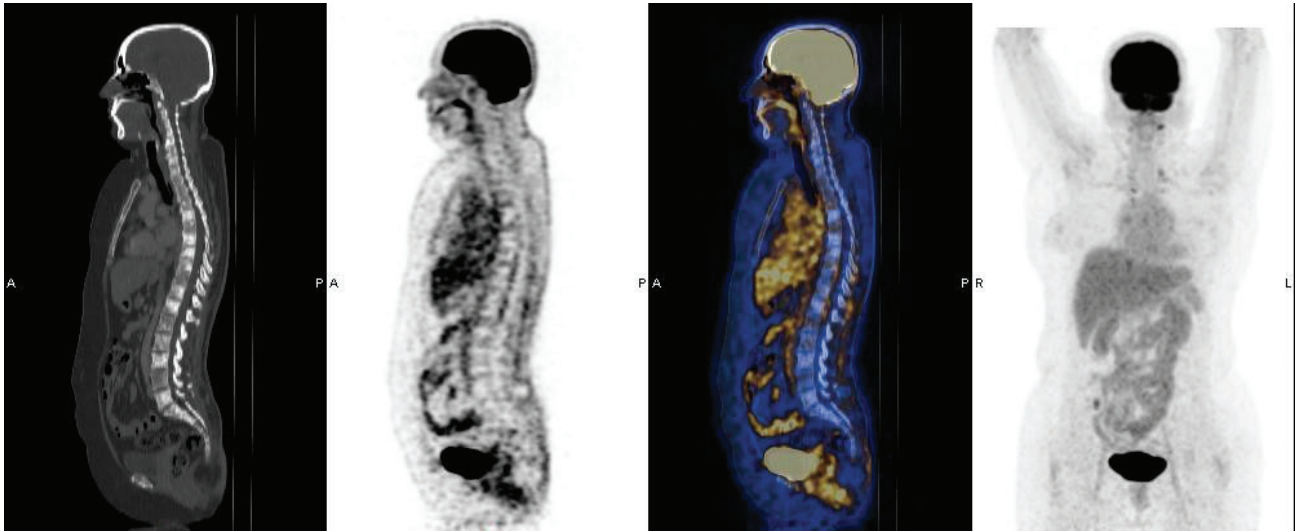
F-18 FDG PET-CT scan after 1 year of treatment showed multiple sclerotic osseous lesions with no FDG avidity, likely treatment response.
